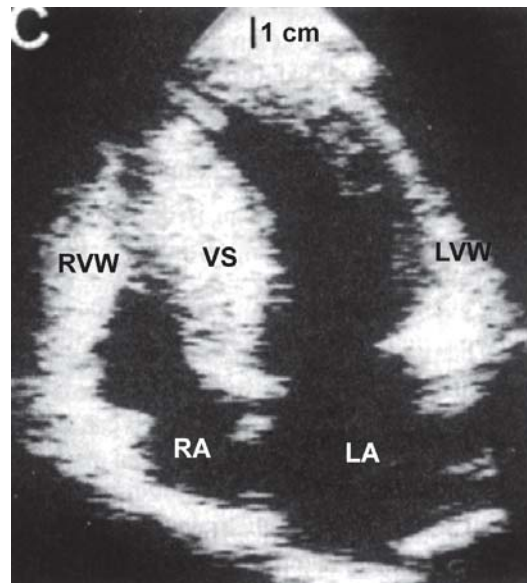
2-D echocardiography (apical 4-chamber view) showing gross hypertrophy of the interventricular septum (VS) that measures 4 cm as also remarkable hypertrophy of the free walls of the ventricles (LVW, RVW), each measuring 3 cm. *Diagnosis:* hypertrophic cardiomyopathy
